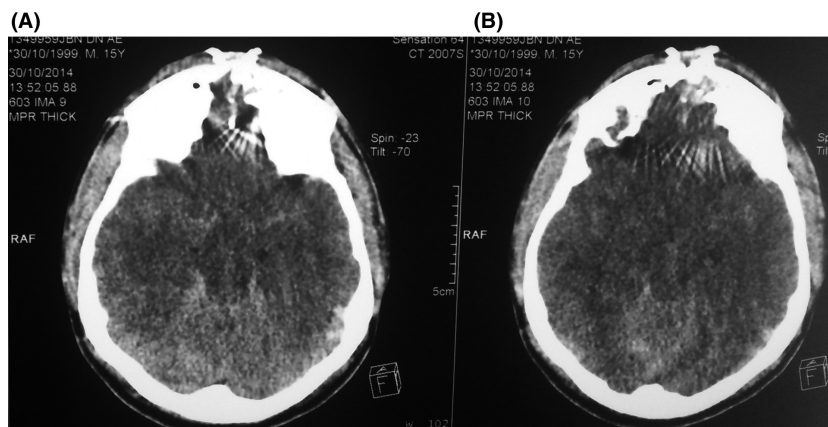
(A, B) Computed tomography of the brain showed cerebral edema and compression of the brain stem.
